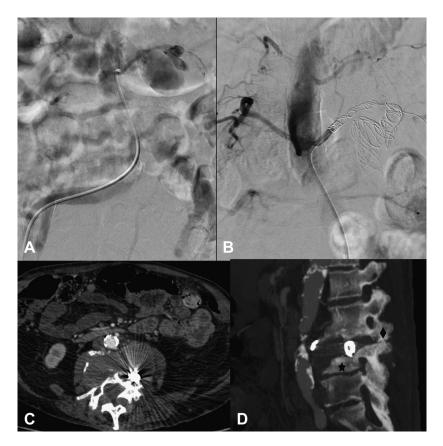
A, Selective left lumbar artery catheterization locating the pseudoaneurysm. B, Left lumbar arteriogram showing no more filling of the pseudoaneurysm after its coil embolization in addition to embolization of proximal and distal parts of the lumbar artery. C and D, Enhanced computed tomography (CT) scan plain and sagittal views displaying coils in lieu of the destructed upper part of L4 and lower part of L3. *Diamond* = posterior articular process of L3; *star* = residual body of L4.
